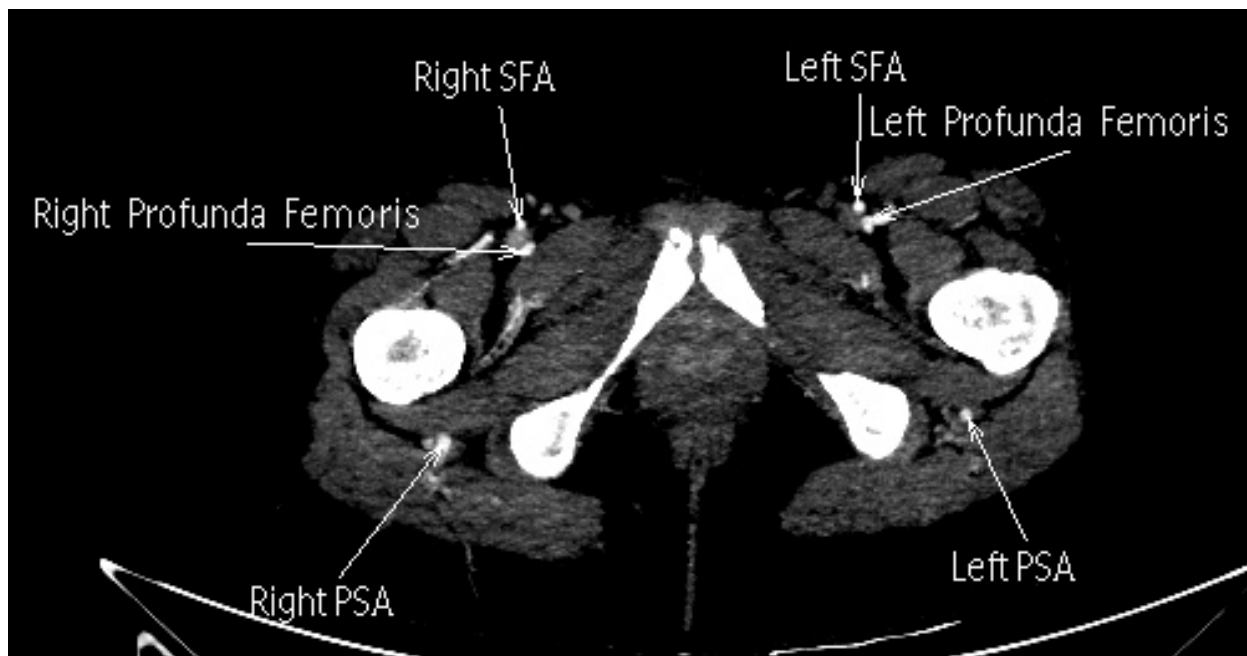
Axial CTA maximum intensity projection (MIP) reconstruction with bone structures demonstrating the relation of the PSAs with the pelvis and proximal femurs. [CTA, computed tomography angiography; PSAs, persistent sciatic arteries.]
